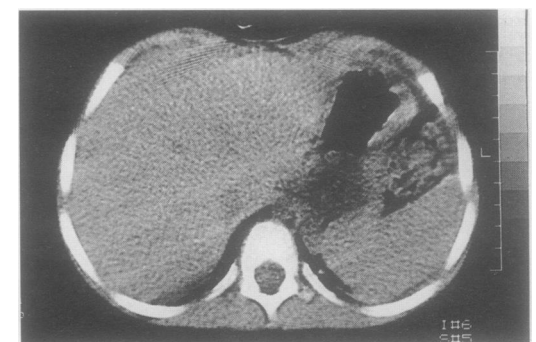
Computed tomogram after two months' interferon gamma showing resolution.
